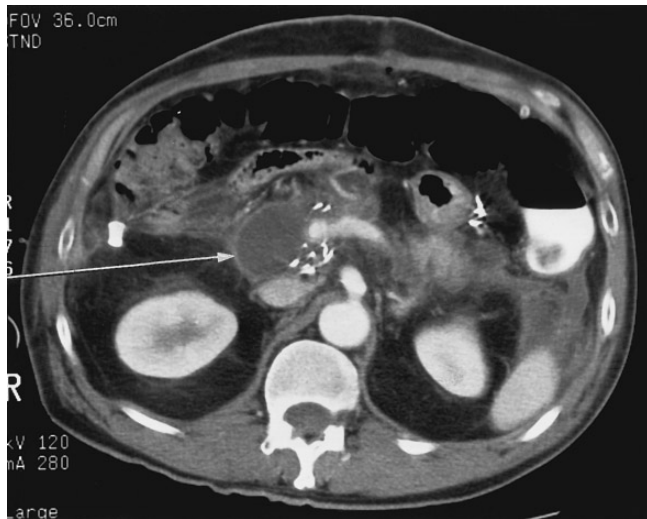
Contrast-enhanced CT scan in a 48-year-old man with clinical signs of infection 1 week following pancreaticoduodenectomy. A rim-enhancing fluid collection is present in the bed of the resected pancreas. Percutaneous access was obtained along the route indicated by the white arrow, fluid was sent for culture, and a 12 Fr sump catheter was placed.
